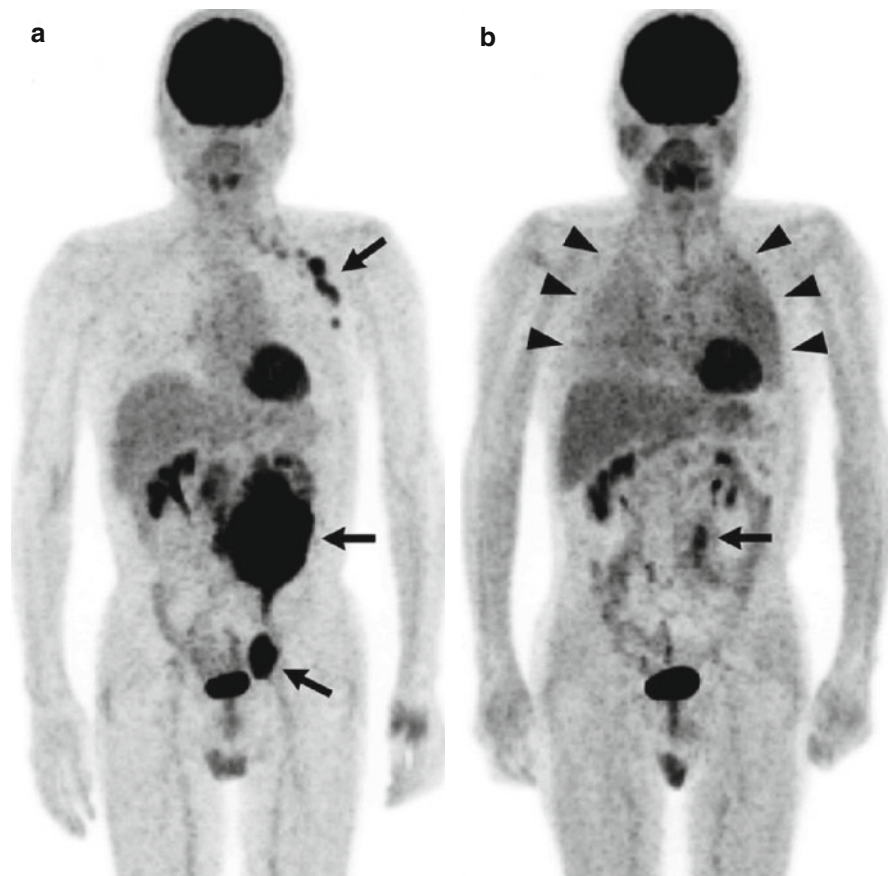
(a) Initial FDG-PET image of a diffuse large B-cell lymphoma. Abnormal uptake is observed corresponding to the bulky mass in the left abdomen and in the left axillary, para-aortic, and para-external iliac artery lymph nodes (*arrows*). No increased uptake was observed in the lung. (b) FDG-PET after five courses of chemotherapy. Decreased, but persistent uptake by the bulky mass in the left abdomen was observed (*arrow*), whereas the uptake by the other lymph nodes was no longer
